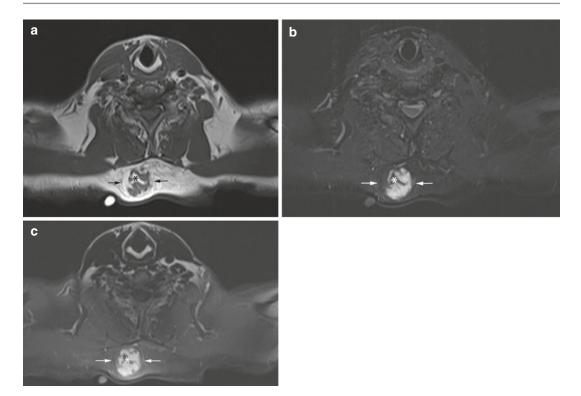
(a–c) Spindle cell lipoma within the subcutaneous tissues of the neck. (a) Axial SE T1-weighted MR image. (b) Axial fat-suppressed SE T2-weighted MR image. (c) Axial fat-suppressed SE T1-weighted MR
